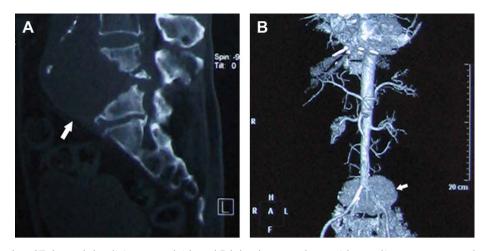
(A) Lumbar CT showed the disintegrated 4th and 5th lumbar vertebrae with an adjacent para-vertebraal abscess (white arrow). (B) CTA revealed an iliac artery pseudoaneurysm of $10 \times 9 \times 6.5$ cm³ (white arrow).
